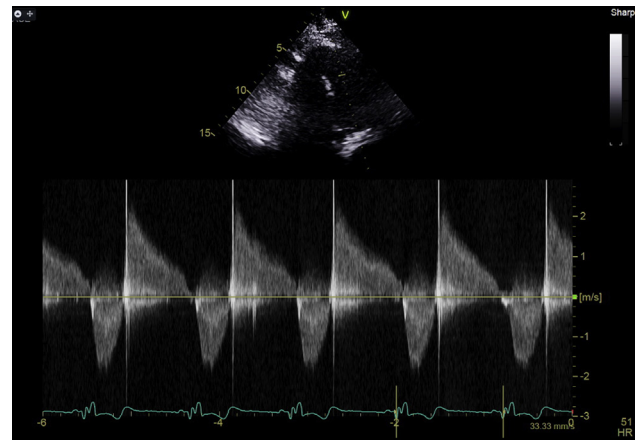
Transthoracic echocardiography, parasternal view, showing RV-PA conduit (continuous-wave Doppler) with no significant stenosis and a normal pulmonary insufficiency velocity.
